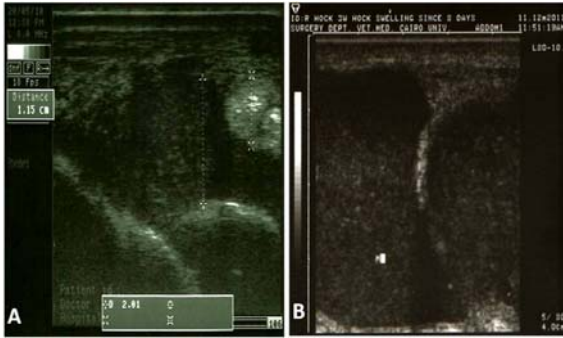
Longitudinal ultrasonogram of dorsomedial recess (A) and medial pouch (B) in septic arthritis of tibiotarsal joint showing accumulation of anechoic fluid filled with hypoechoic dots and synovial proliferation
